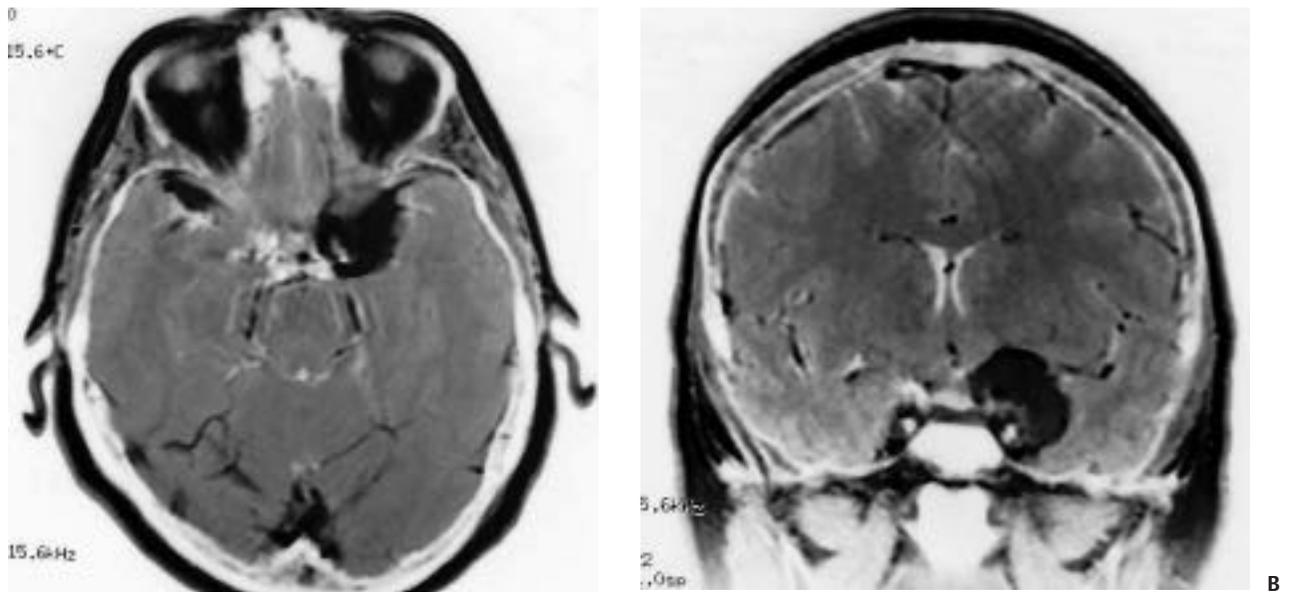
(A) Axial and (B) coronal gadolinium T1-weighted magnetic resonance imaging of the clinoidal meningioma shown in Fig. 24.6, showing the epicenter of the tumor at the level of the left anterior clinoid process.
